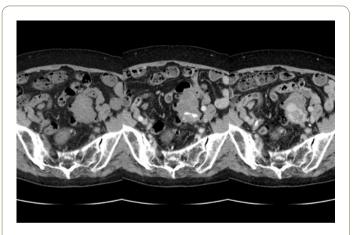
Dynamic CT shows extravasation from a diverticulum.
